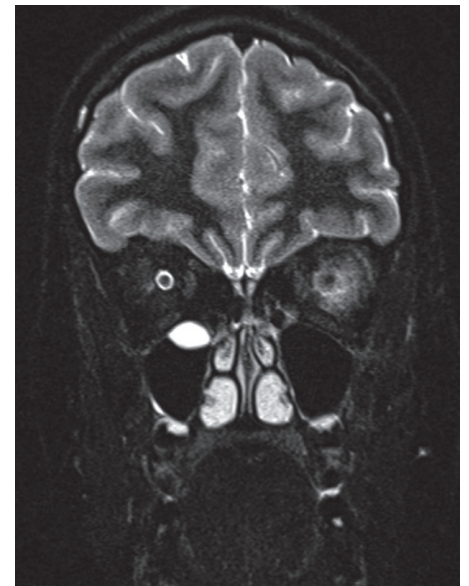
MRI orbital. Coronal TIRM sequence shows left high signal perineural, retrobulbar, and peribulbar and in the glandula lacrimalis.
